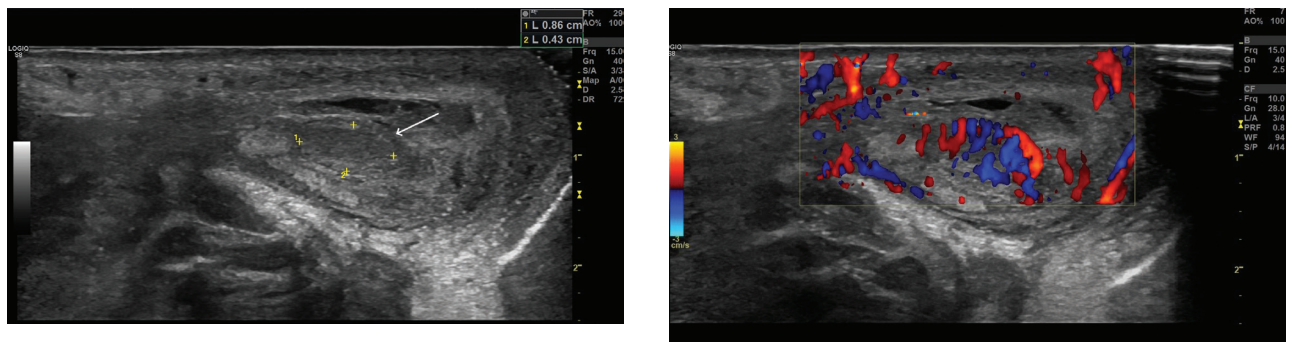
Complicated Amyand's hernia. Longitudinal view of the inguinal canal and the scrotum a. Gray-scale US. The testis (arrow) is recognized homogenous in morphology b. with increased internal blood flow on colour Doppler US.
